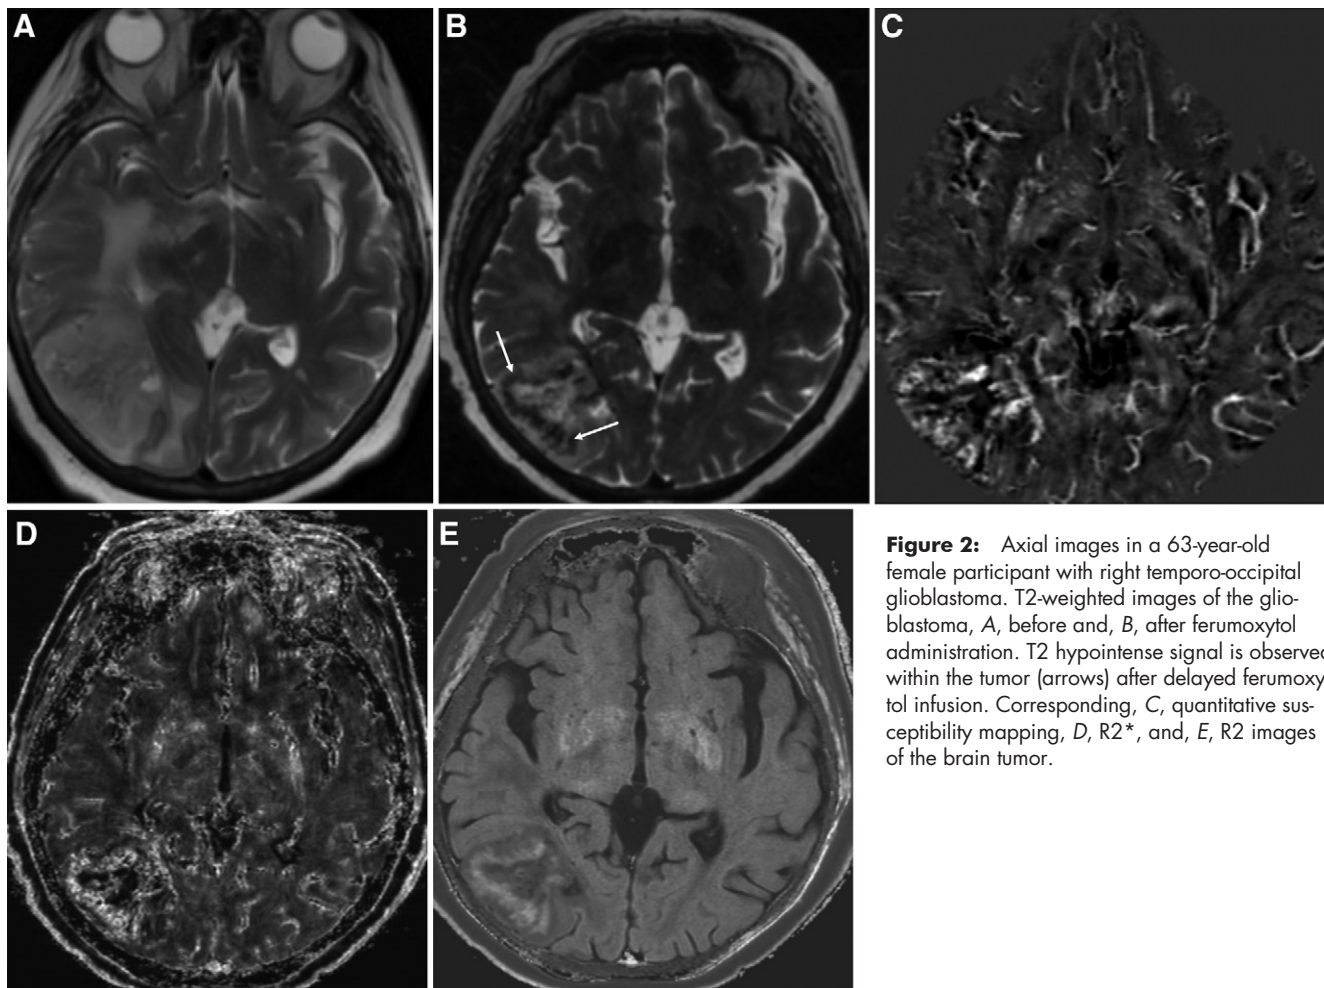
Axial images in a 63-year-old female participant with right temporo-occipital glioblastoma. T2-weighted images of the glioblastoma, *A*, before and, *B*, after ferumoxytol administration. T2 hypointense signal is observed within the tumor (arrows) after delayed ferumoxytol infusion. Corresponding, *C*, quantitative susceptibility mapping, *D*, $R2^*$, and, *E*, $R2$ images of the brain tumor.
